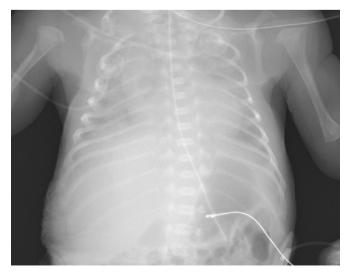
Chest X-ray at birth.
